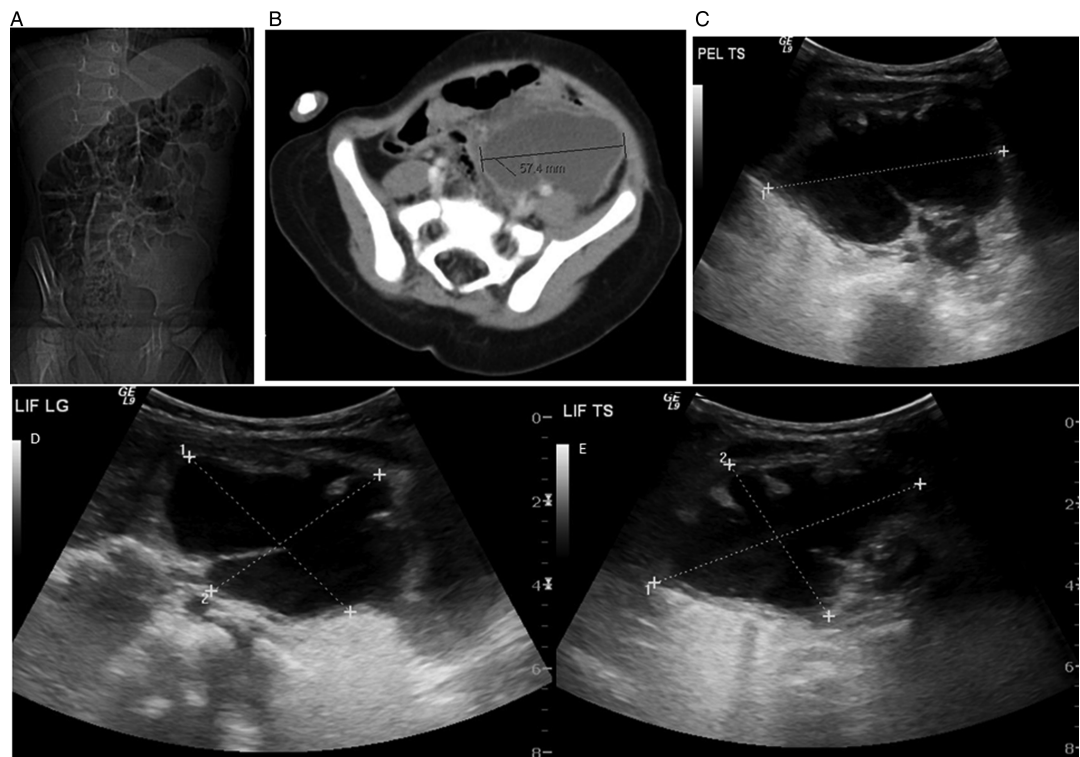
(A) An abdominal scout film showing soft tissue pelvic mass extending to the left lower abdomen and abnormal dilated bowel gas pattern. (B) A CT scan showing a 5.7 cm length cystic structure in the left pelvis with wall enhancement on the pelvic side. (C–E) Transverse and longitudinal ultrasound scans of the pelvis and left iliac fossa showing a cyst with a septa and the double-wall lining in places.
